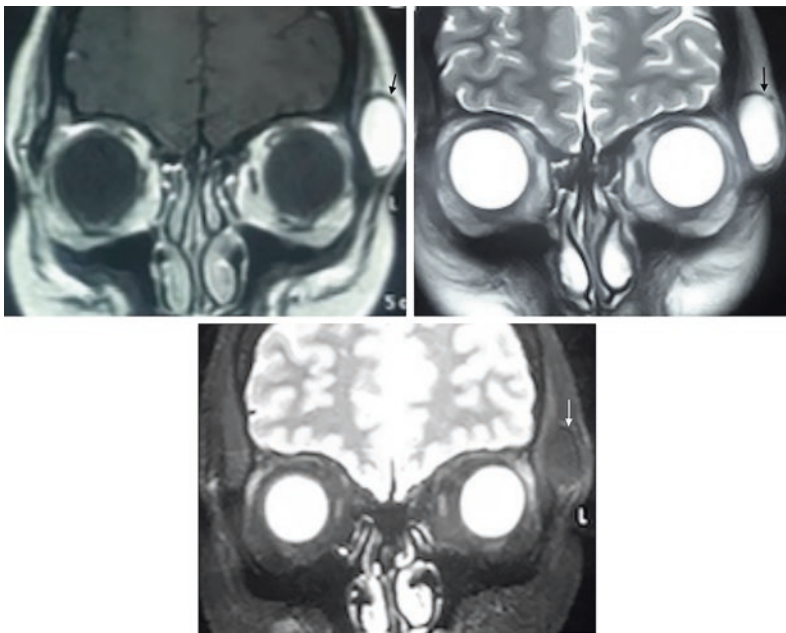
Superficial paraorbital dermoid on MR images. a–c Coronal T1WI, T2WI and T2WI with fat suppression images demonstrate superficial ovoid shaped mass at the superolateral aspect of the orbit. The mass has high T1 and T2 signal with signal drop on fat suppression sequence (arrows)
